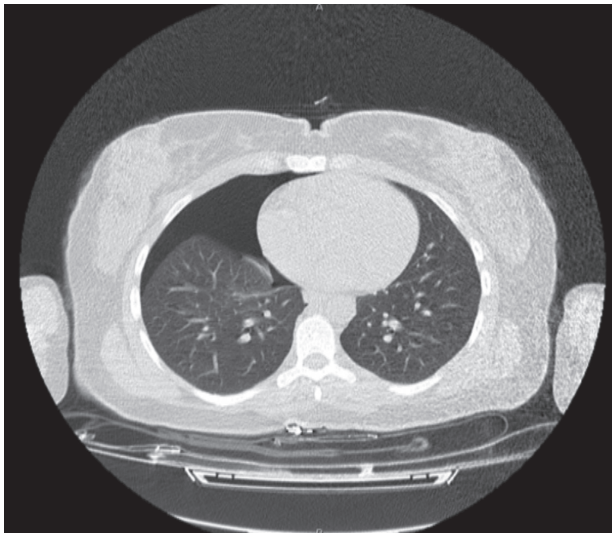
Non-contrast thorax Computed Tomography (CT) scan confirming a large right-sided pneumothorax causing partial collapse of the lung parenchyma.
